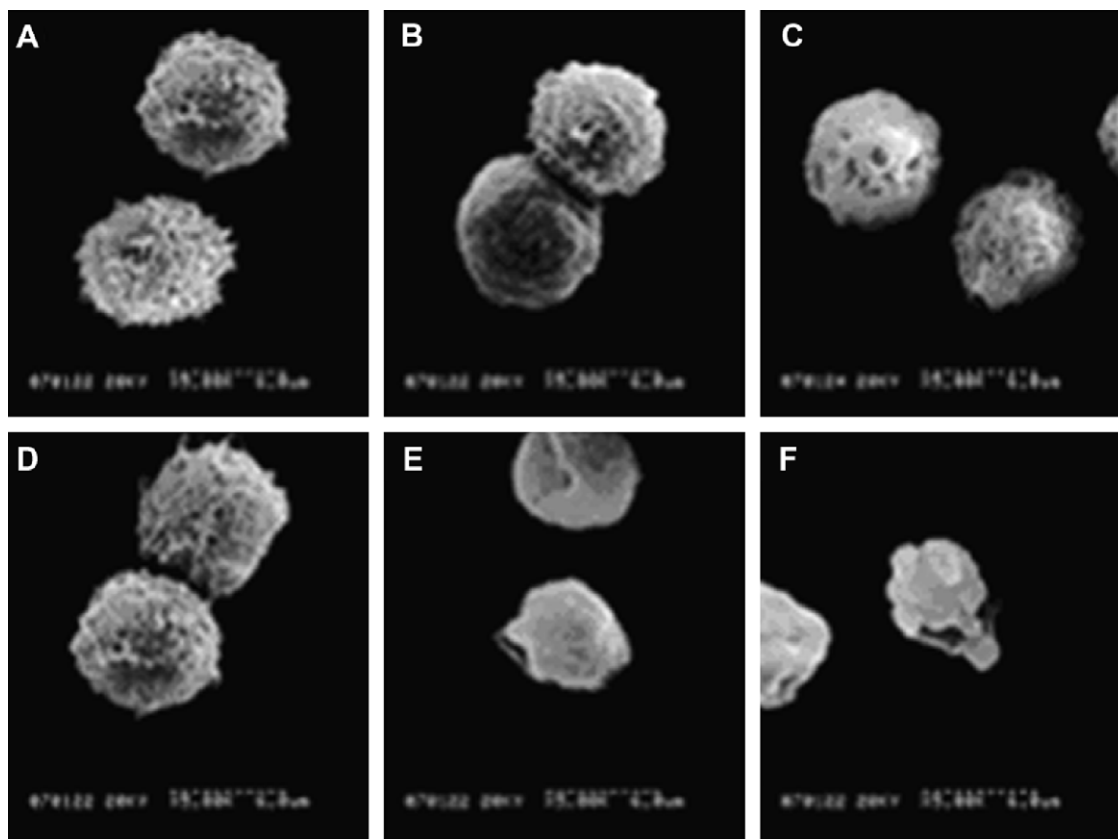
SEM images of EAC cells: (A) control cell; (B, C) cells treated with ultrasound 2 and 4 h later, respectively; (D) cells 4 h after treated with 20 μ M PPIX; (E, F) Cells irradiated with ultrasound plus 20 μ M PPIX after 2 and 4 h of culture, respectively.
